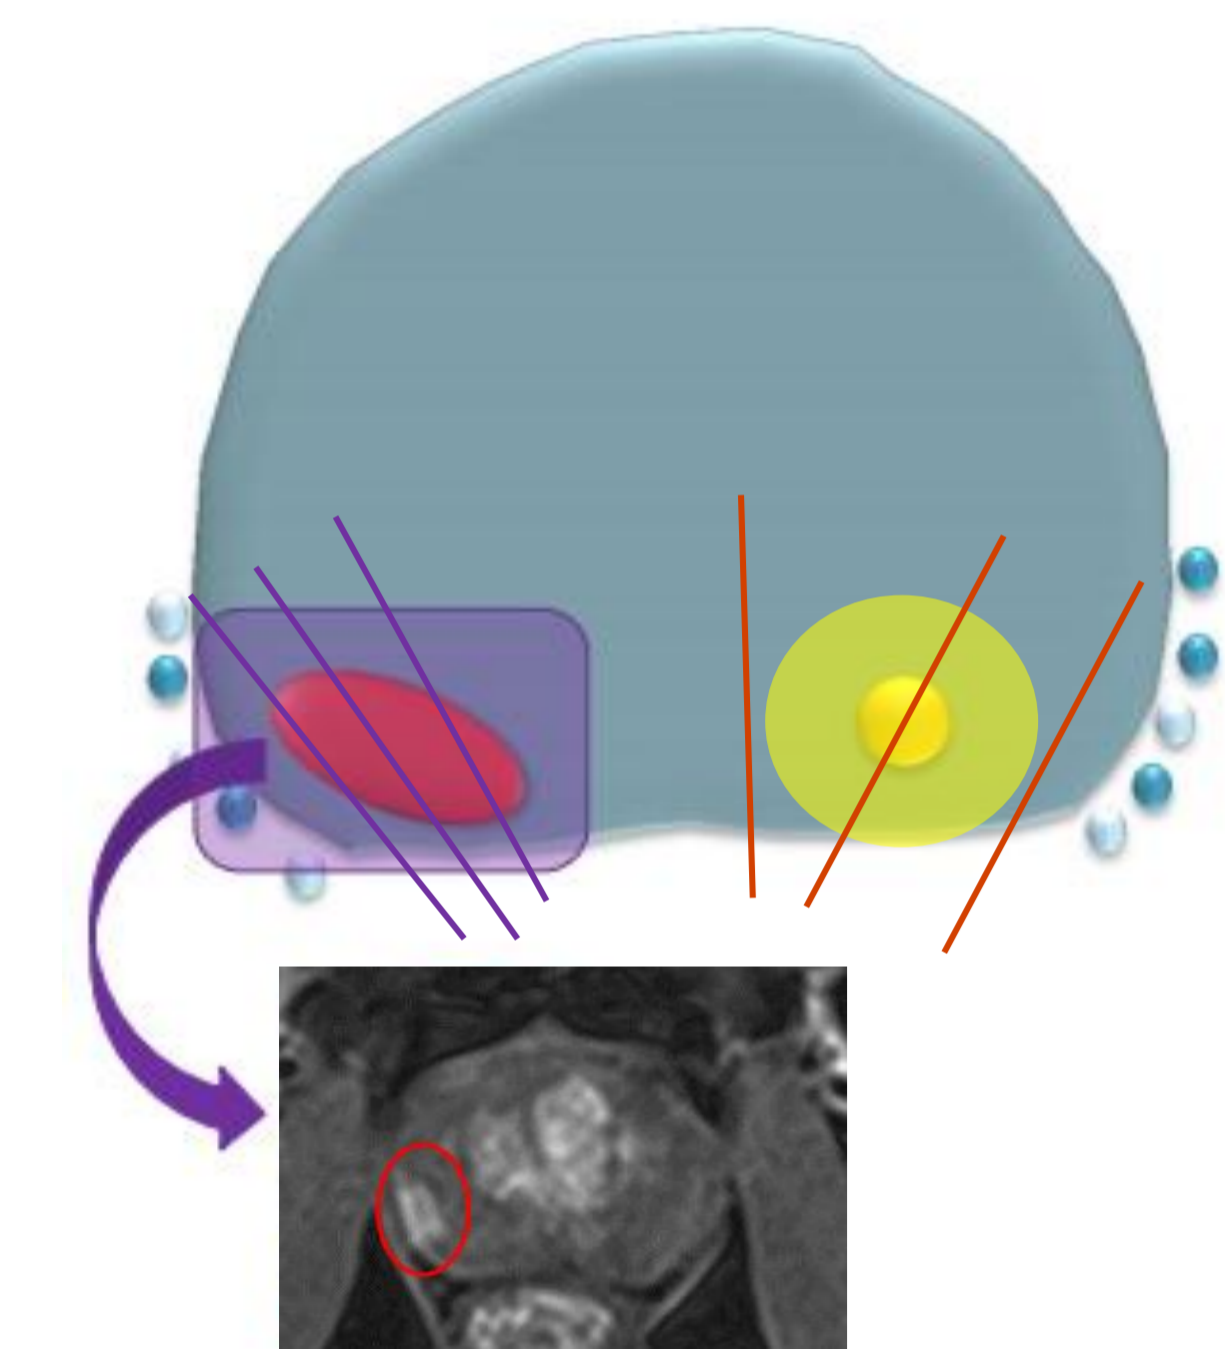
Targeted and systematic biopsy cores in relation to prior mpMRI. Targeted cores (purple line) of prostate tumour (red oval) demonstrated on pre-biopsy MRI (red circle). Second prostate tumour (yellow circle) without region of interest on mpMRI, detected on non-targeted systematic cores (red line).
